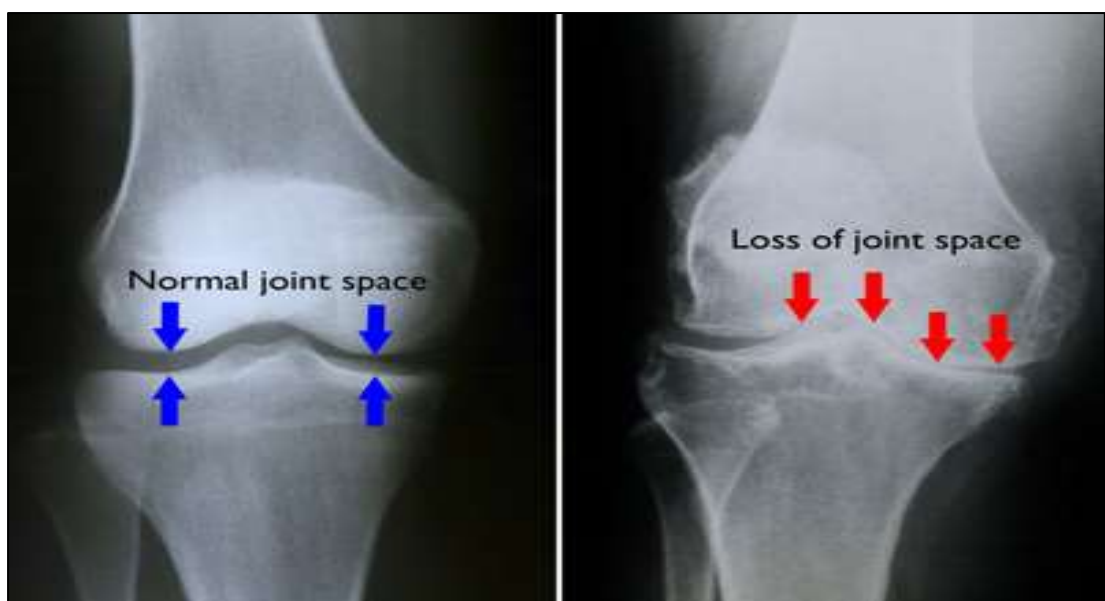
X-ray of normal and osteoarthritis knee
